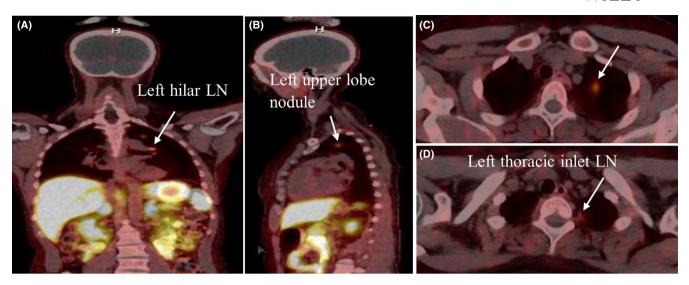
[68Ga]-DOTATATE PET/CT demonstrated focal uptake in the upper lobe of the left lung (A, B, C), two foci of uptake in the left hilar region (A), and a left thoracic inlet lymph node (LN) (D) [Colour figure can be viewed at wileyonlinelibrary.com]
